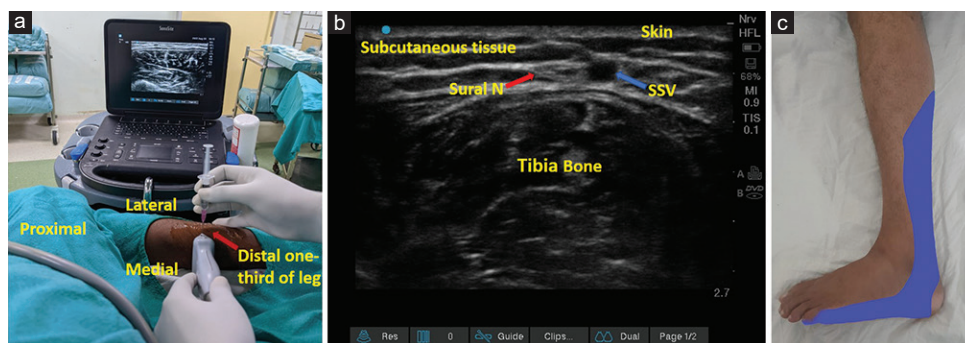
(a) Probe position at the middle and lower third of the posterior aspect of the leg for ultrasound-guided SN block; (b) Sonoanatomy of SN; The area of sensory innervation of SN (blue). SN: Sural nerve
